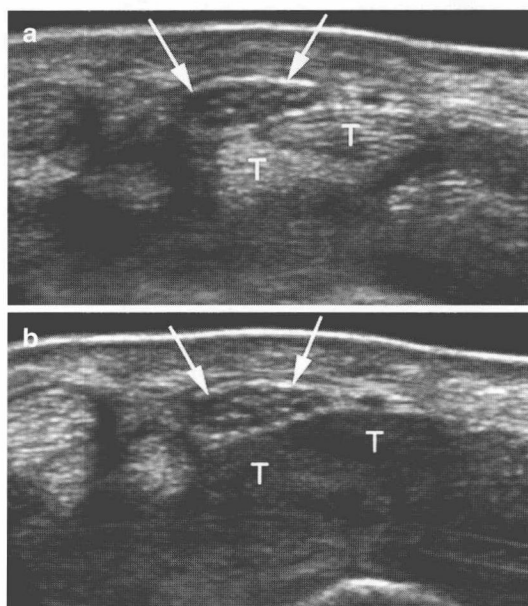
Transverse ultrasound images through the median nerve (arrows) in a healthy volunteer taken with a 17 MHz transducer on a Philips IU22 with different transducer tilt position. Note the marked change of flexor tendon (T) signal from hyperechoic in (a) to hypoechoic in (b) but only minimal change of the median nerve
